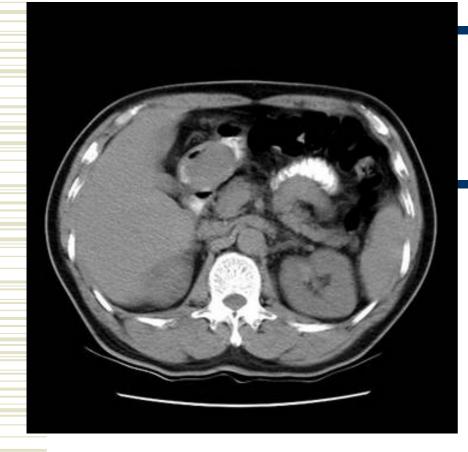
Image Findings – Abdominal CT with and without contrast
